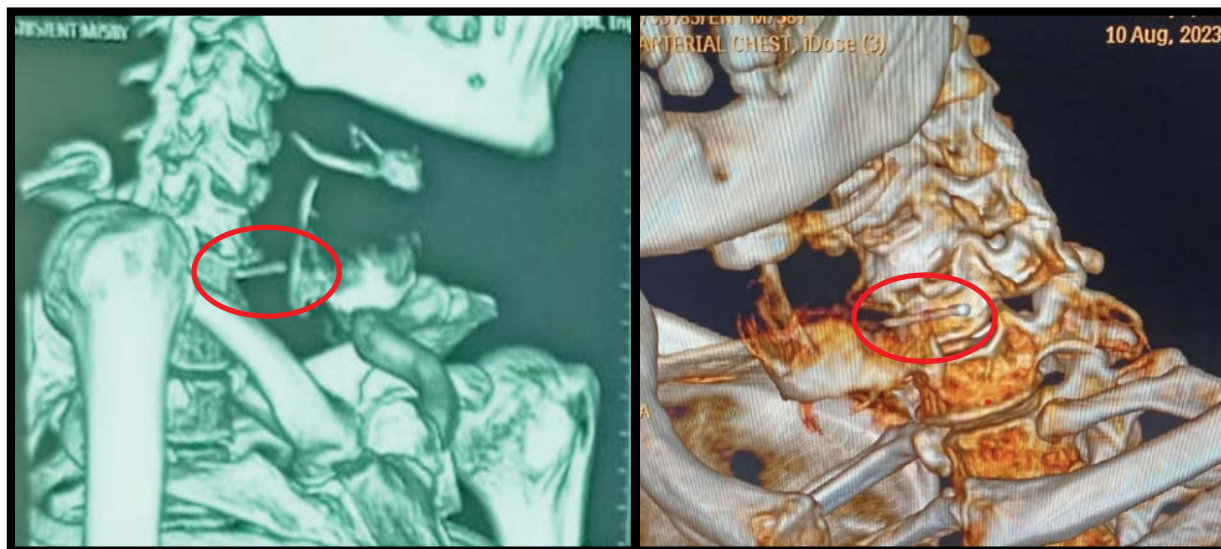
and 2B : 3D reconstructed Computerized tomography (CT) view of the Foreign body (red outlined) in the prevertebral space with a close relation to the cervical vertebral column (C5,6 level).
